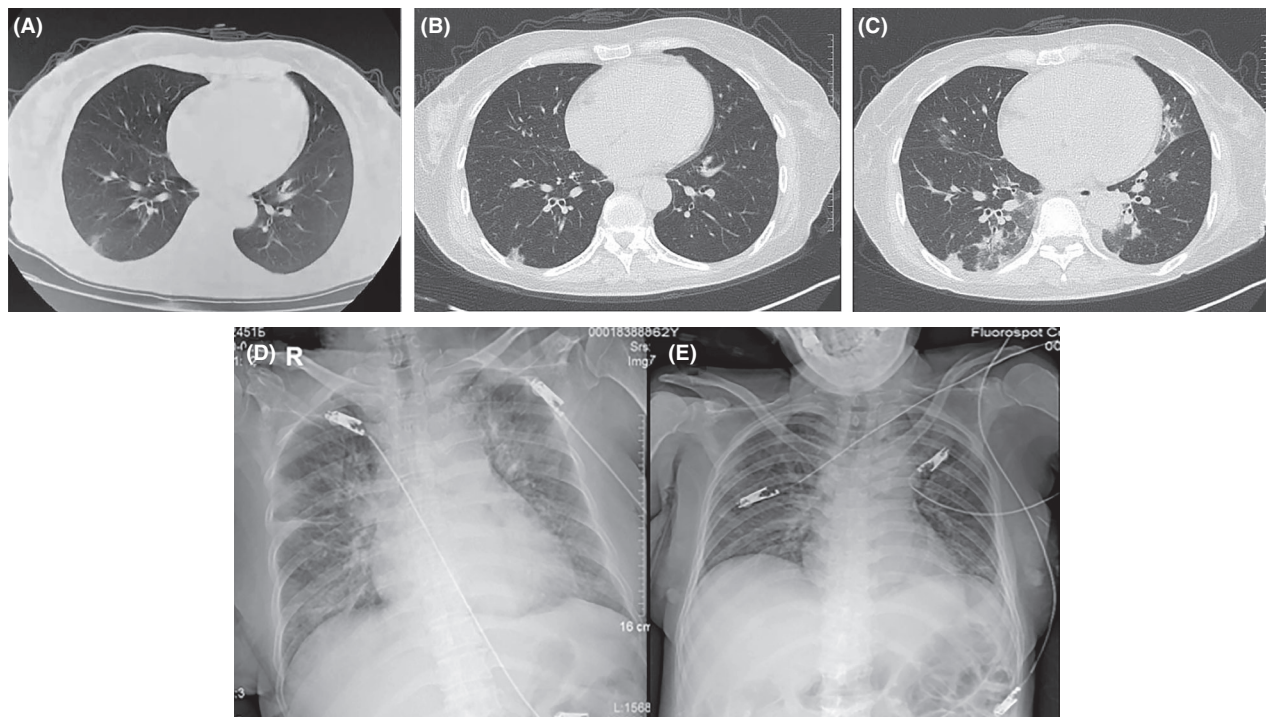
Radiological characteristics of the chest. (A) Day 1, mild infusion in the right lung in CT; (B) Day 6, mild infusion in the right lung in CT, without obvious deterioration; (C) Day 17, expansion of the lung lesions in CT; (D) Day 22, patchy high-density shadow in both lungs in X-rays; (E) Day 29, substantial improvement with a reduction of pulmonary exudative lesions in X-rays.
